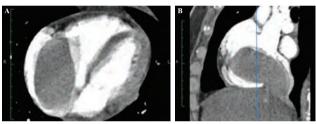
(A) CT scan of the thorax shows the intracardiac extension of the intravenous leiomyoma. (B) CT scan of the thorax shows the intracardiac extension of the intravenous leiomyoma.
